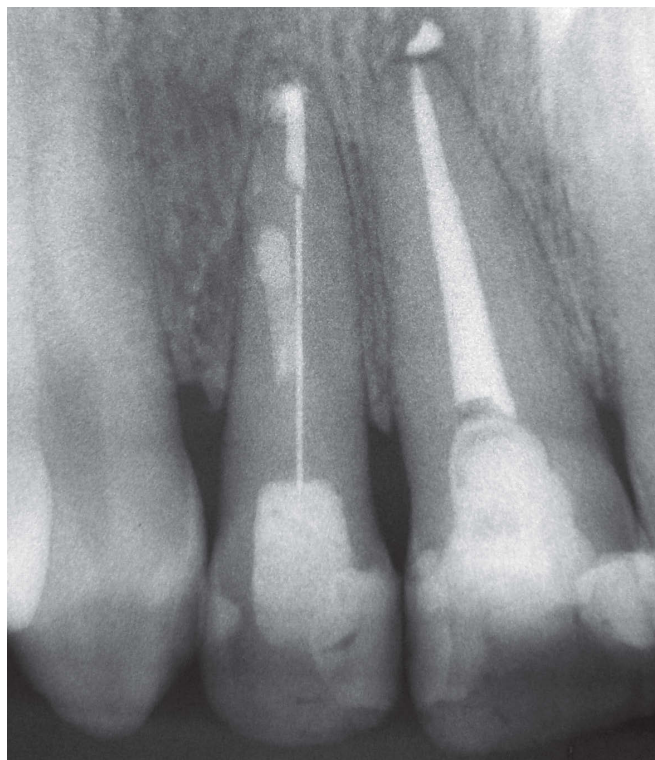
24-month follow-up tomograph. Note intact periodontal ligament, absence of periapical radiolucency and intact lamina dura surrounding the tooth.
